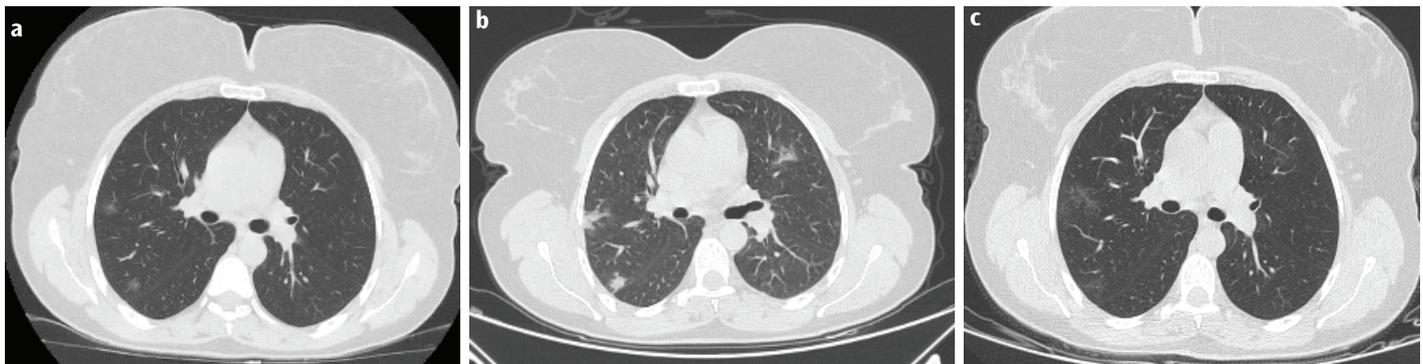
a-c. CT scans in a 49-year-old woman with coronavirus 2019 pneumonia. Axial CT image (a) obtained 3 days after the onset of initial symptoms (stage-1) shows round and patchy GGOs distributed around the subpleural area of right upper and middle lobes. Axial CT image (b) obtained 7 days after the onset of initial symptoms (stage-2) shows increased density on right lobe lesions which mainly became consolidations and a patchy ground-glass opacity is newly developed in left upper lobe. Axial CT image (c) obtained 30 days after the onset of initial symptoms (stage-6) shows patchy residual GGOs in both upper lobes and right middle lobe
